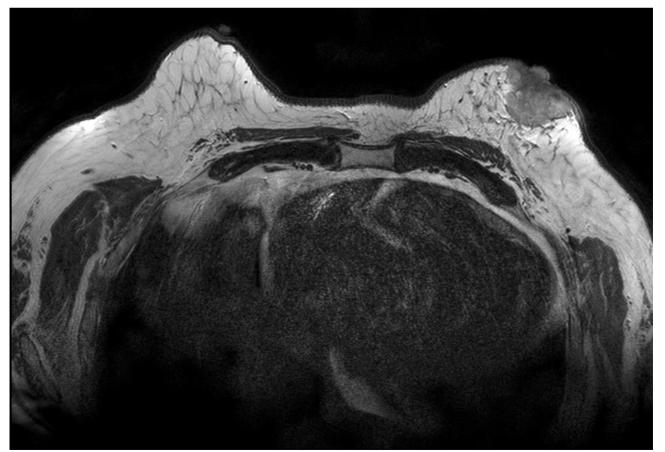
Breast MRI, T2-weighted image. The lesion had intermediate signal intensity on T2-weighted image.
